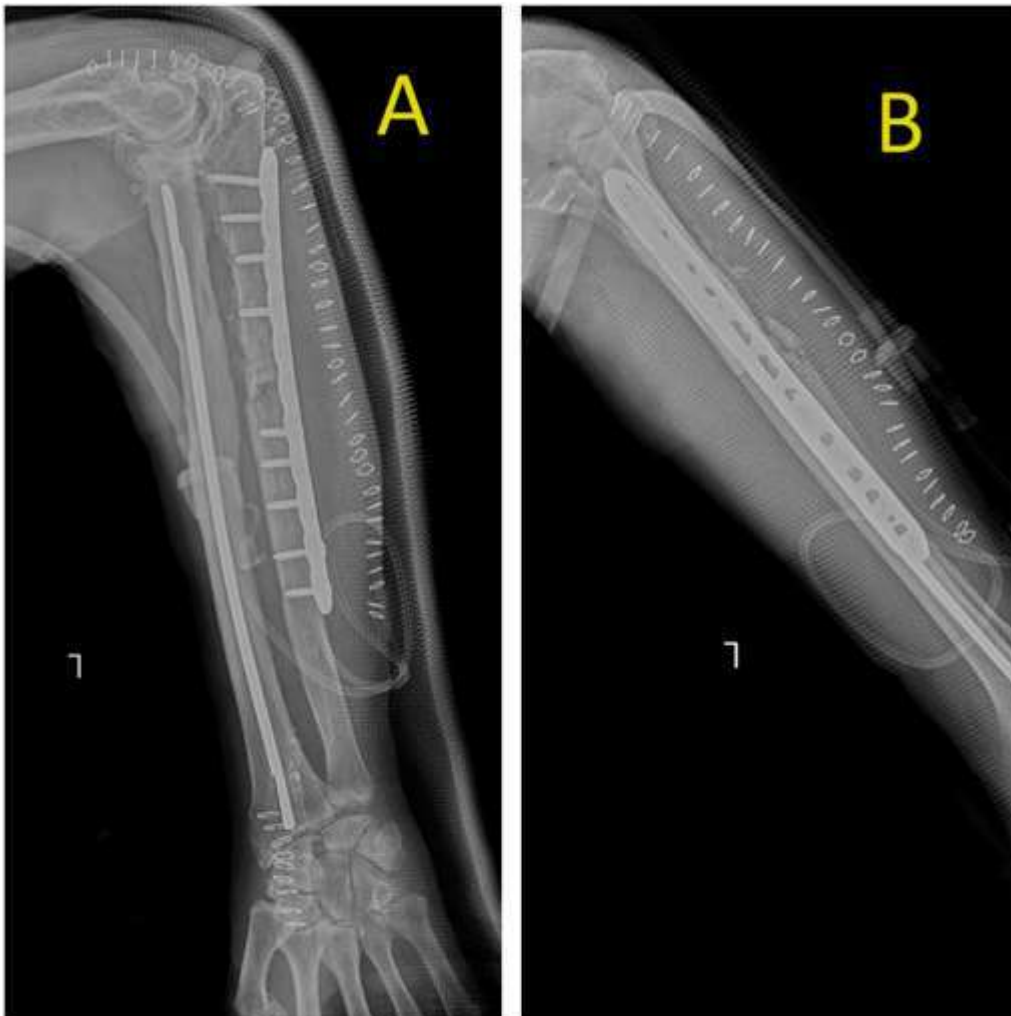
Immediate postoperative Anteroposterior (AP) and lateral forearm radiographs showing fixation of ulnar nonunion with a plate.
